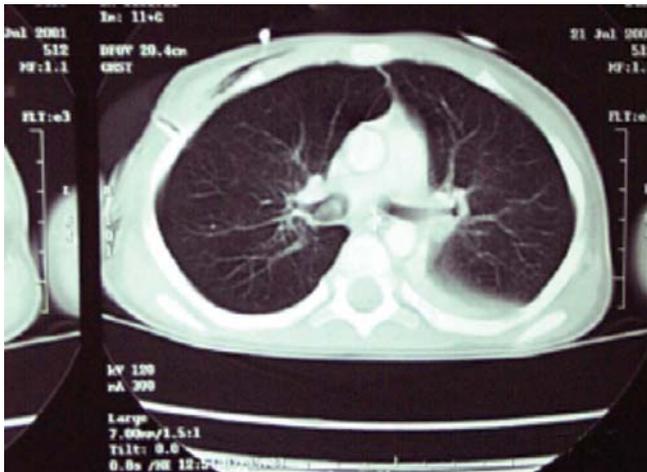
CT scan showing foreign body in right mainstem bronchus
